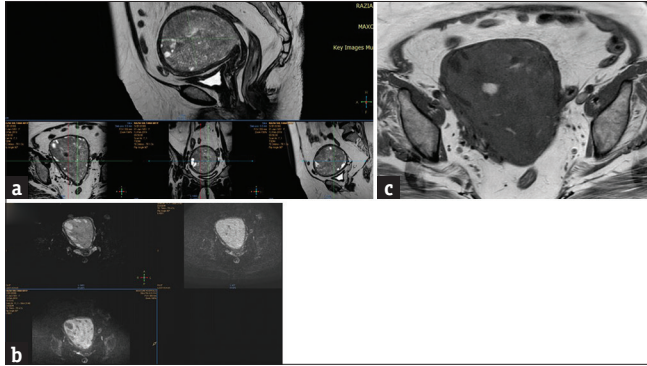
Giant endometrial Polyp: Multiplanar T2-weighted image. (a) Sagittal images delineated markedly distended endometrial cavity with smooth compressed uterine myometrium all around and normal cervical canal confirming that it developed within the uterine cavity positioned centrally, signal predominantly showing T2 shine through on diffusion-weighted image. (b) Apparent diffusion coefficient value within the high signal diffusion-weighted image mass was 1.3–1.4 and within the cyst was 2.1–2.3. On plain T1-weighted images (c) reveal the mass mainly isointense on plain T1 images with intratumoral cysts along the periphery and central hemorrhagic areas (hyperintense on T1W, hypointense on T2-weighted, Blue arrows). Ultrasound examination (not shown) revealed a 86 mm mass within the uterus with some central vessels at Doppler examination
